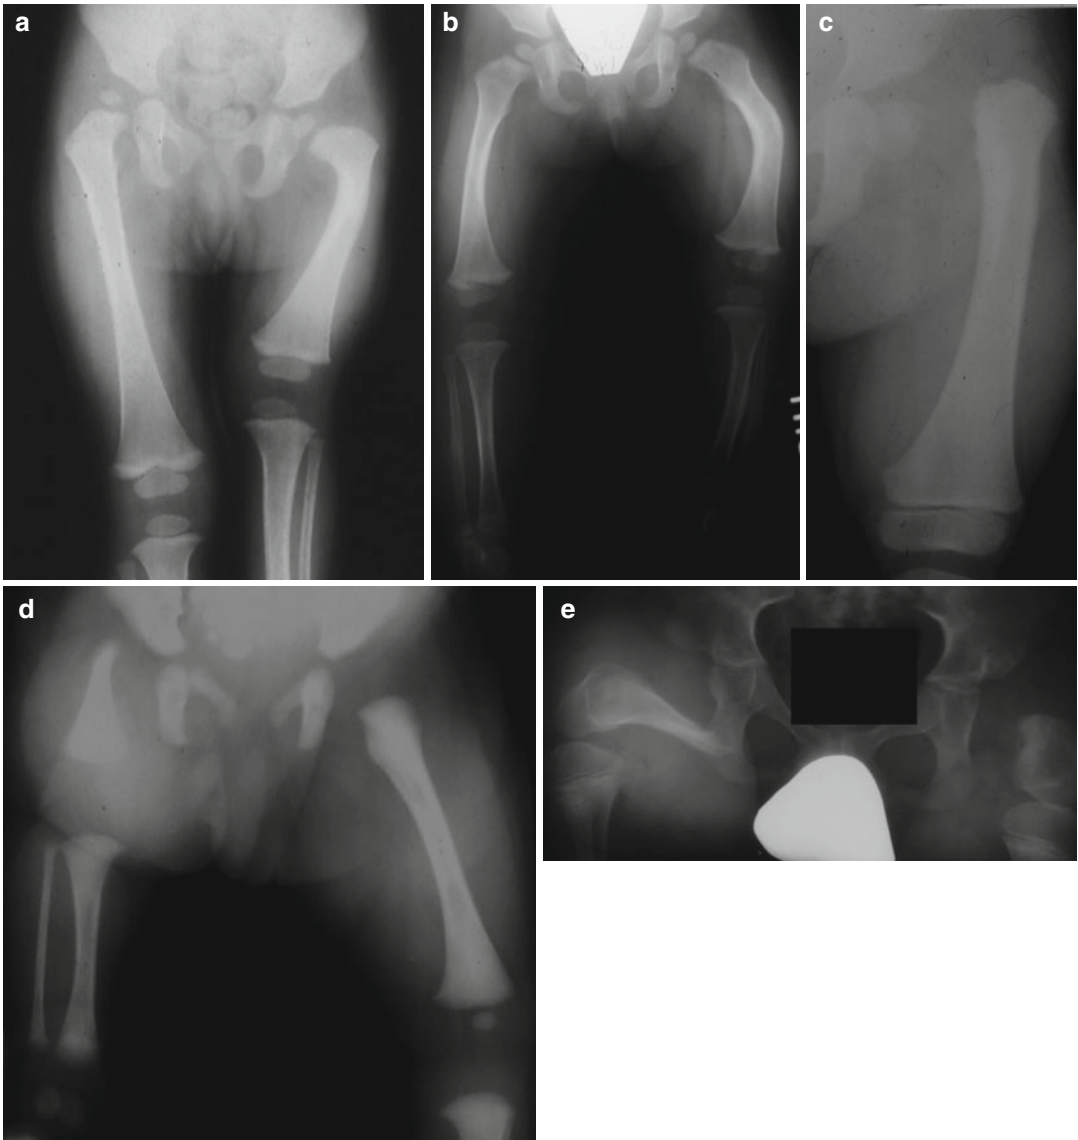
Variations in the radiographic appearance of children with proximal femoral focal deficiency (PFFD): (a) A congenital short femur with minimal bowing. (b) A congenital short femur with moderate bowing. (c) A mild
